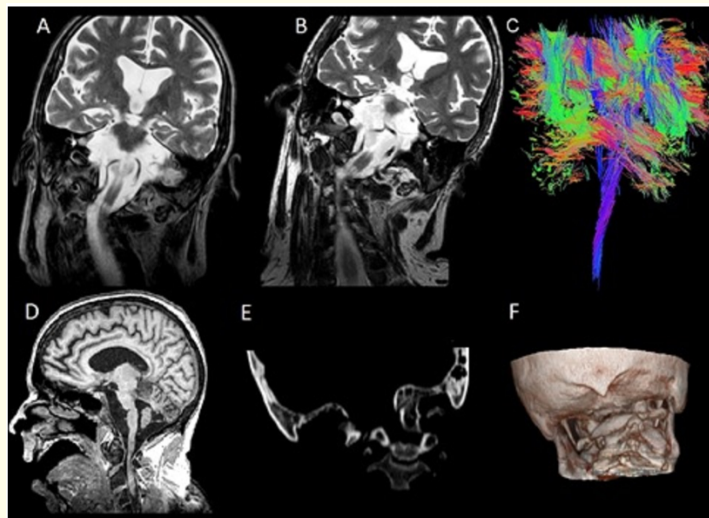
A-B: MRI (T2, coronal view), shows brainstem deformity and T2 hyperintensity in the lower part of the medulla oblongata suggesting the presence of an old infarct. C: Tractography reveals twisting of long tracts along the brainstem. D: MRI (T1, sagittal view) showed severe atrophy of the brainstem. E-F: CT-3D showing a rotatory upper spine dislocation.
